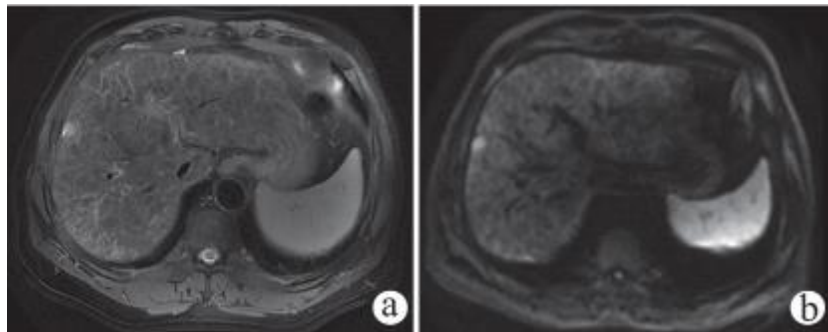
MRI feature of a small HCC associated with liver
